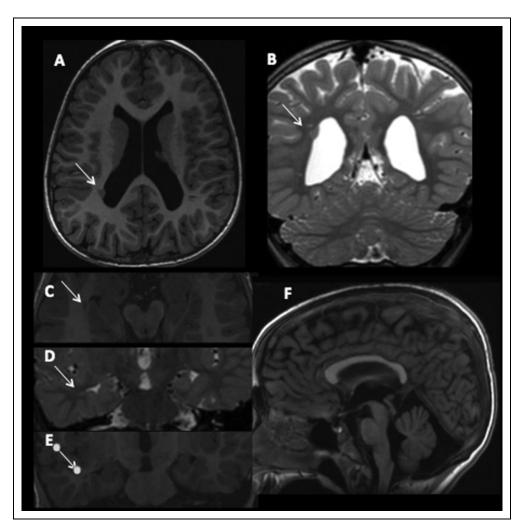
Axial TI-weighted image (A) and coronal T2-weighted (B) image show nodule of heterotopic gray matter protruding into trigone of the right lateral ventricle. Wider than usual lateral ventricles. Axial TI-weighted (C), coronal T2-weighted (D), and coronal TI-weighted images show a further small nodule of gray matter into white matter lateral to ventricular temporal horn. Sagittal TI-weighted image (F) shows a mild thinning of corpus callosum and enlarged pericerebellar cisterns.
